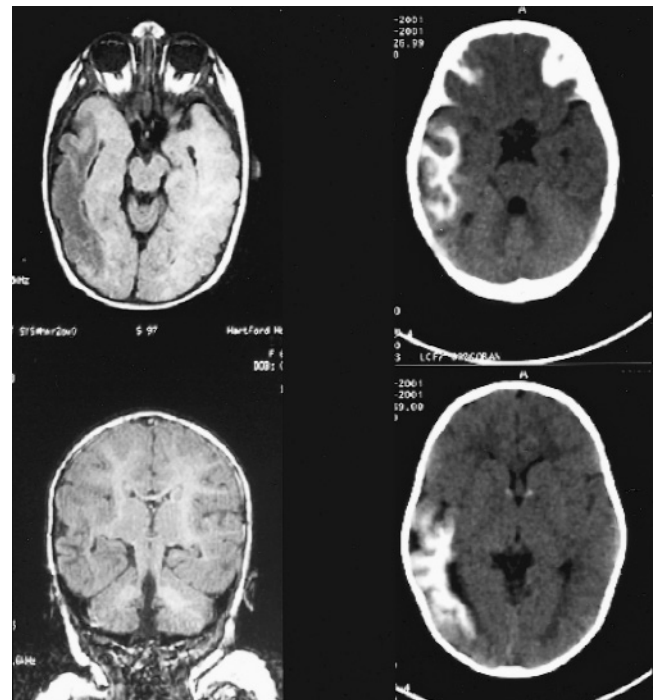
Transmantle cortical dysplasia. The upper and lower panels on the right show axial noncontrast computed tomographic scans displaying extensive calcification of the entire right temporoparietal lobe. The upper panel on the left shows the corresponding T_1 -weighted magnetic resonance image (MRI), whereas the lower panel on the left shows the corresponding coronal T_1 -weighted MRI.
